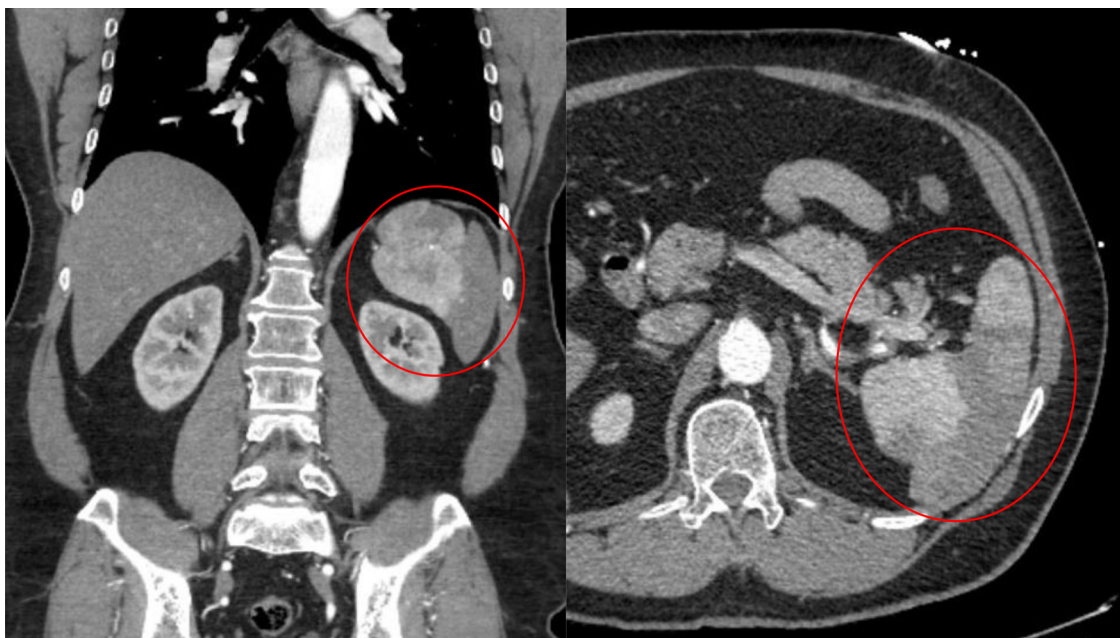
Coronal and axial CTA demonstrating splenic infarction.
